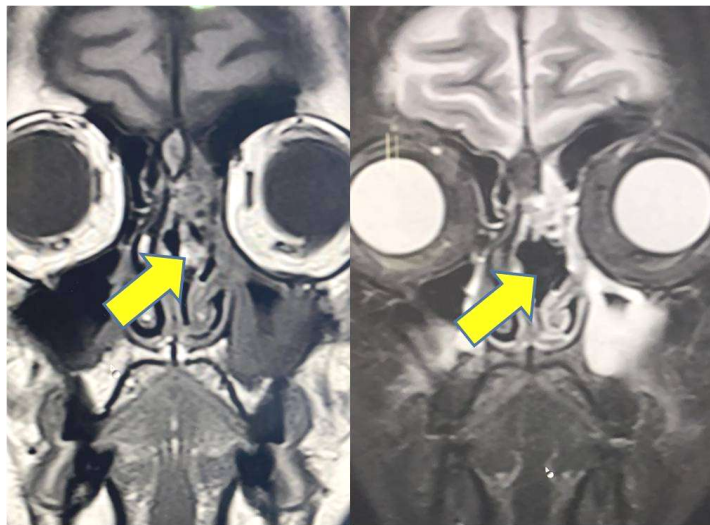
Turbinate mucormycosis. Coronal T1 and T2FS MRI: focal high signal at left middle turbinate on T1W (arrow); the same area appears low signal on the T2FS MRI (arrow). Inflammatory changes at ethmoid and maxillary sinuses.
